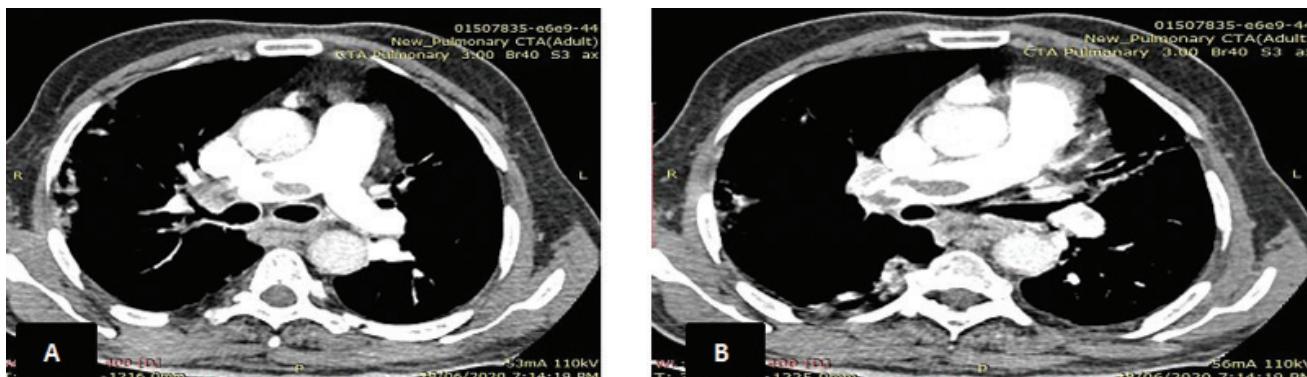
CT Pulmonary Angiography. (A, B) Computed tomography pulmonary angiography demonstrates multiple filling defects involving lobar and segmental branches of the right pulmonary artery.
